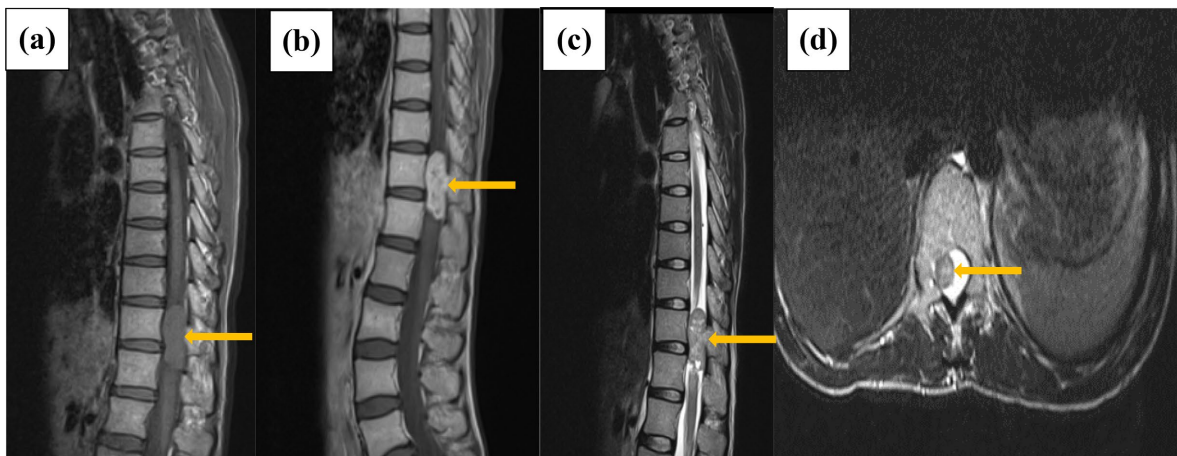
Spinal MRI with gadolinium contrast. (a) Sagittal T1-weighted image showing an ovoid, isointense lesion at the T12-L1 level. (b) Sagittal T1 with gadolinium. (c) Sagittal T2-weighted image showing the lesion as heterogeneously hyperintense. (d) Axial T2-weighted image demonstrating displacement of the spinal cord to the right, compressed by the left-sided tumor.
